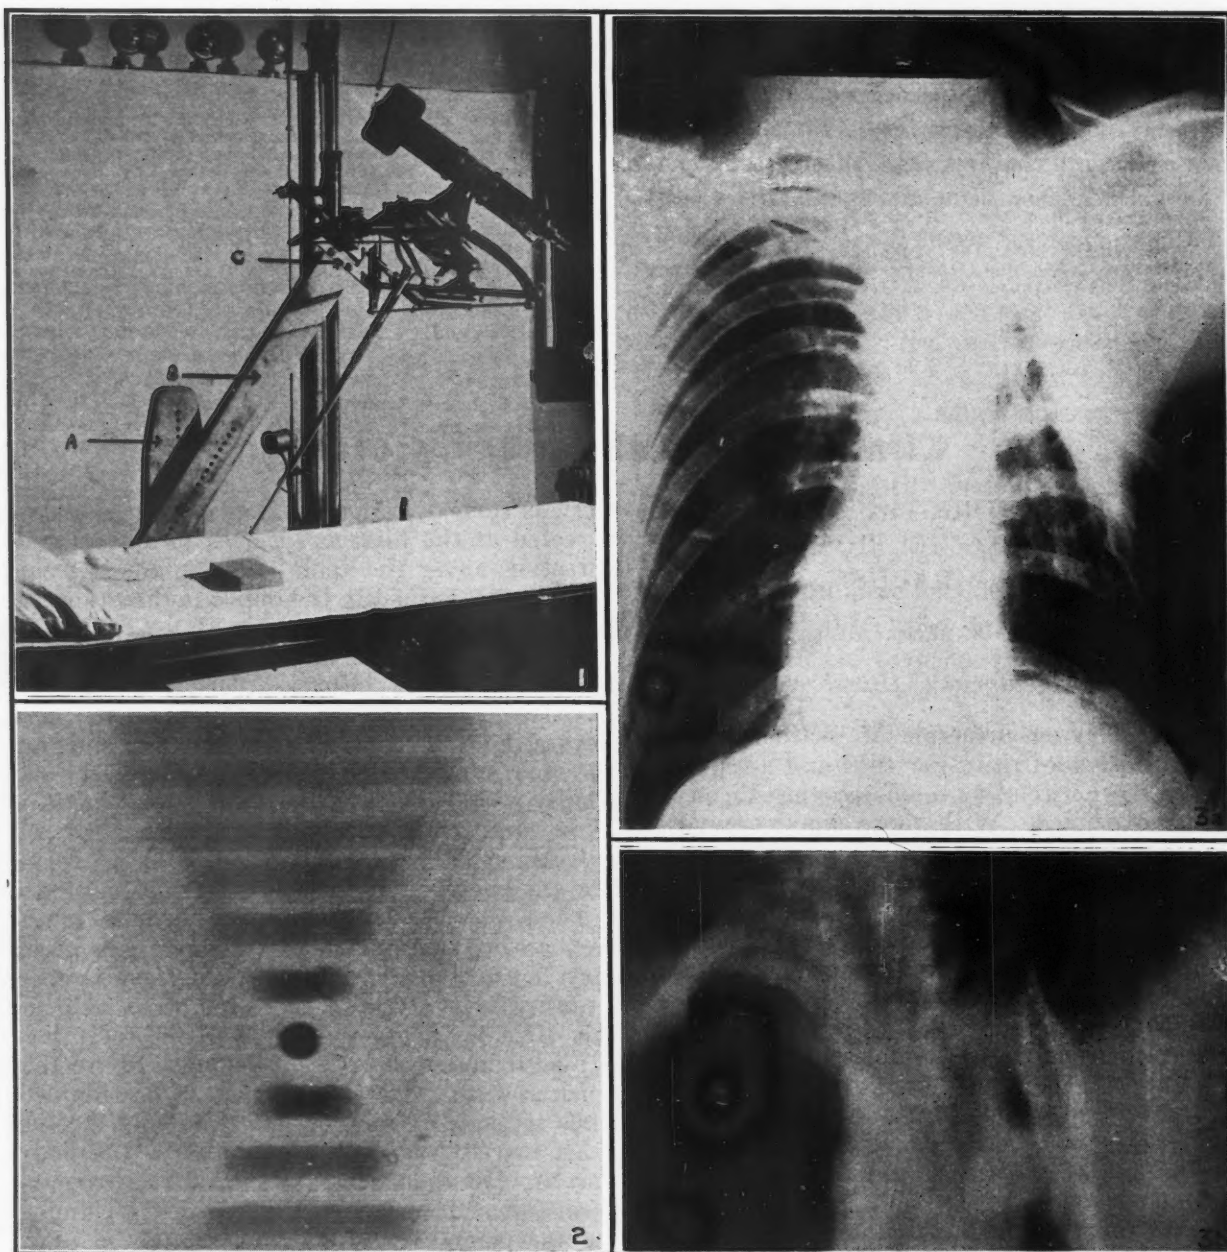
The apparatus. Note central ray as indicated by pointer directed at the film. A. Upright hardwood bar. B. Swinging hardwood bar. C. Iron bar attached to tube carriage. Fig. 2.—Radiograph of lead shot, at levels $\frac{3}{8}$ inches apart. Note the sharpness of the shot in the plane of the fulcrum. Fig. 3a.—Radiograph of chest following thoracoplasty. No cavity seen. Fig. 3b.—Same case as Fig. 3a. Sectional radiograph outlines cavity sharply.
